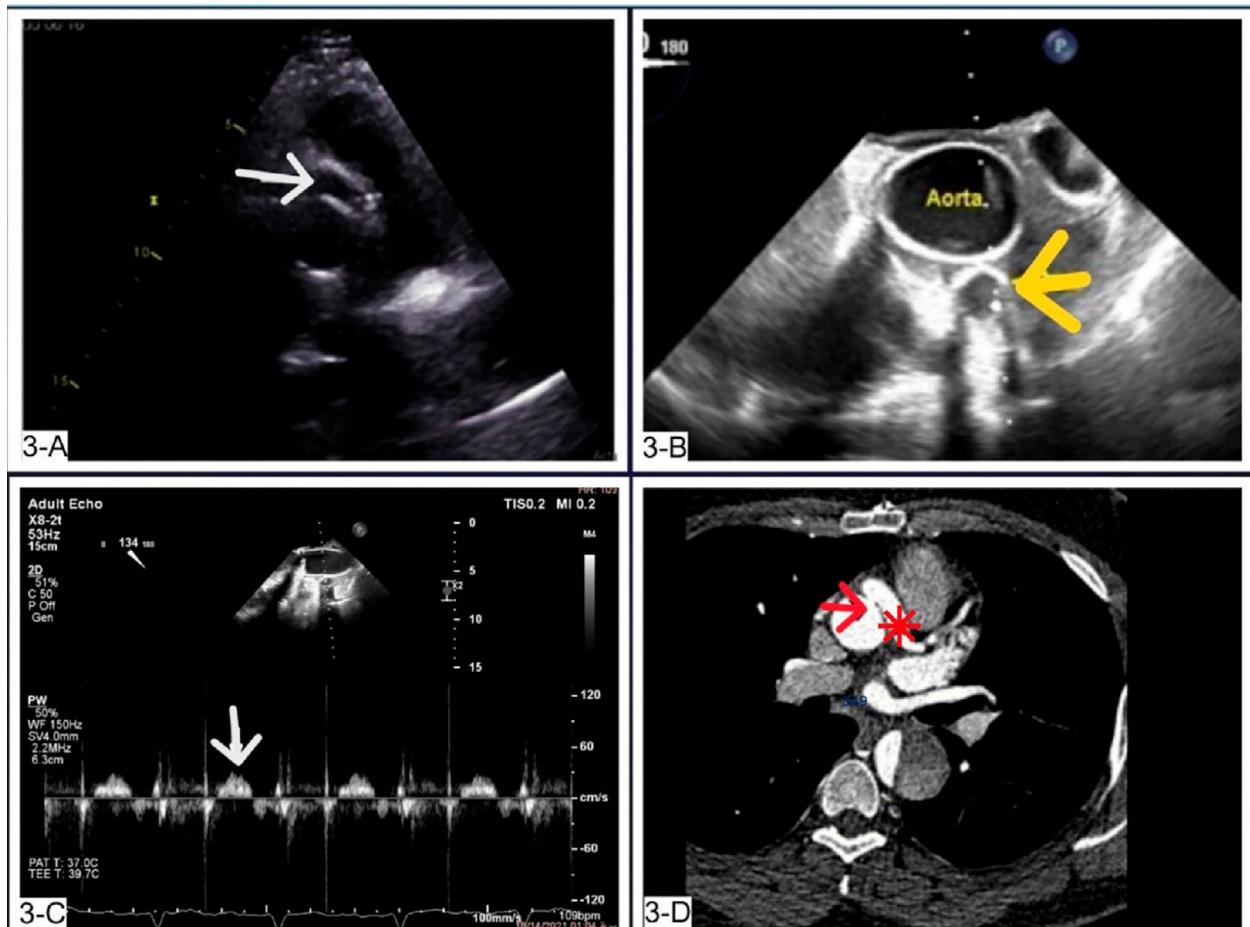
(A) Cabrol tube on the transthoracic short axis parasternal view (white arrow), (B) transesophageal echocardiography shows a textured tube graft (Cabrol anastomosis) in the anterior side of the ascending aorta (yellow arrow). (C) Doppler image of coronary diastolic flow (white arrow) through the Cabrol tube graft on the transesophageal echocardiography. (D) Coronary CT angiography performed 35 months post-surgery reveals a patent Cabrol anastomosis to the ascending aorta conduit (red arrowhead), a patent Cabrol to the left main coronary artery connection (red asterisk), and patent coronary arteries.
